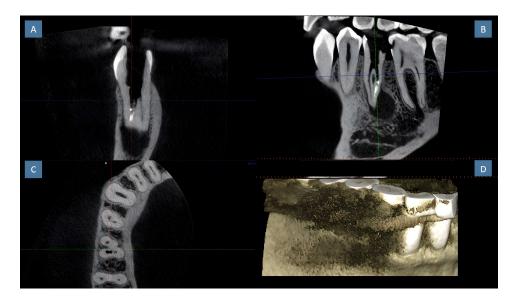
The CBCT sections that are displayed in four different views: (A) Coronal, (B) Sagittal, (C) Axial, and (D) a three-dimensional image.
